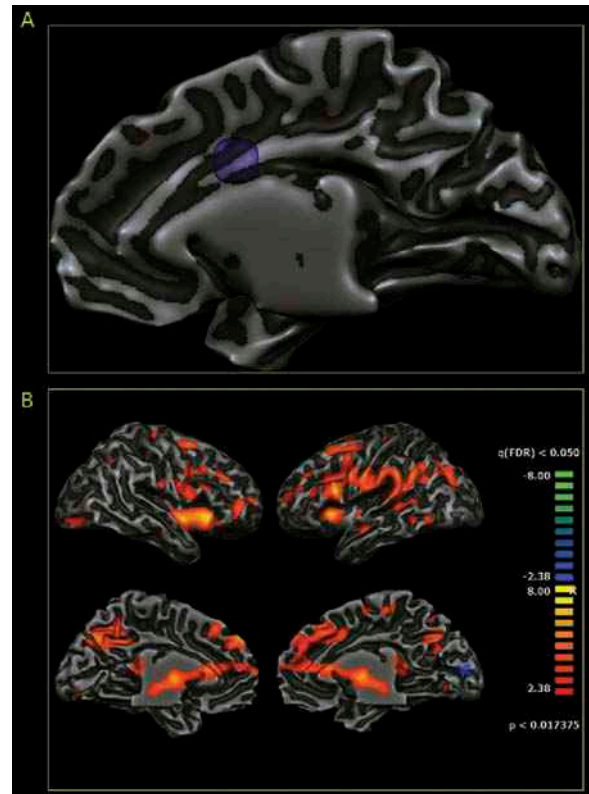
Functional MRI results for the “no-go” minus “go” conditions, in the comparison between aware ( $n = 3$ ) minus unaware ( $n = 2$ ) patients. Maps were thresholded at  $q < 0.05$  cluster level. Panel A: The ROI activation cluster is projected on a 3D brain surface with Brain Voyager QX 2.1. Panel B: The associated activated network derived by the whole-brain analysis.
